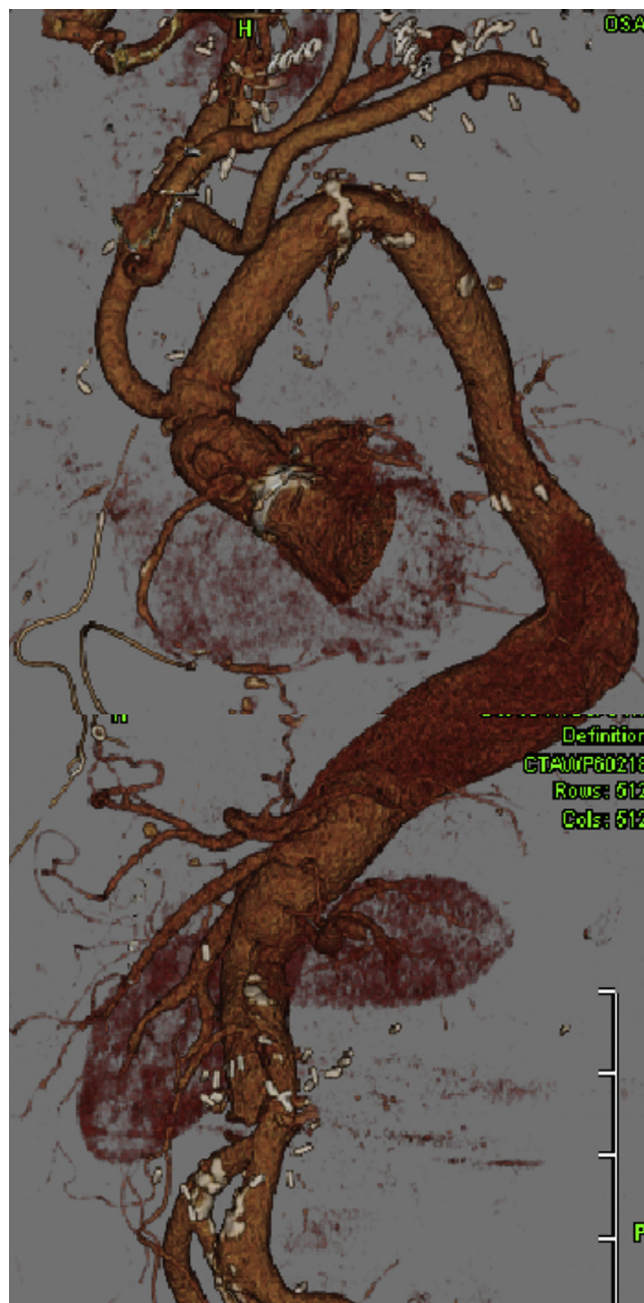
Postoperative 3D CT. The false lumen in the thoracic aorta was thromboexcluded, with abdominal visceral perfusion from the false lumen preserved through the fenestrated site.
